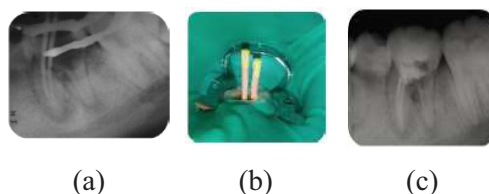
(a) Radiographic view trial master cone; (b) fitting of guttapercha cone; (c) Root canal treatment- post obturation.
